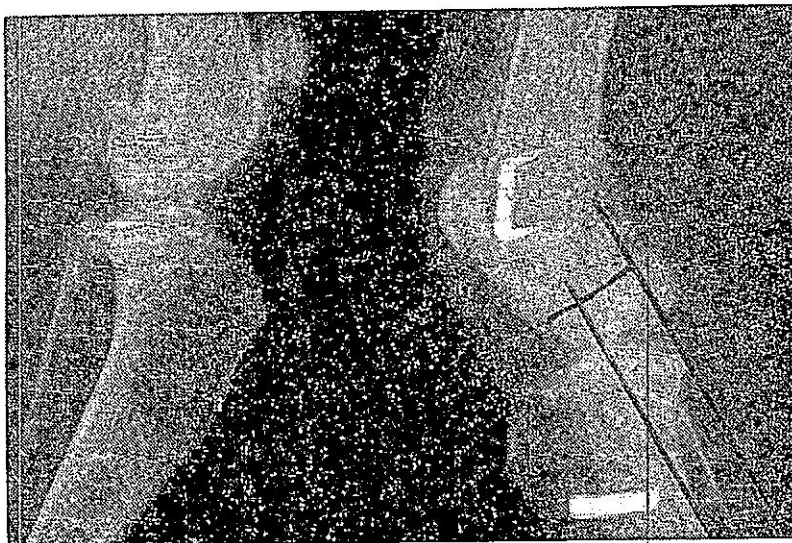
The stress radiographic picture showing minimal anterior shift picture of the stable knee joint.
